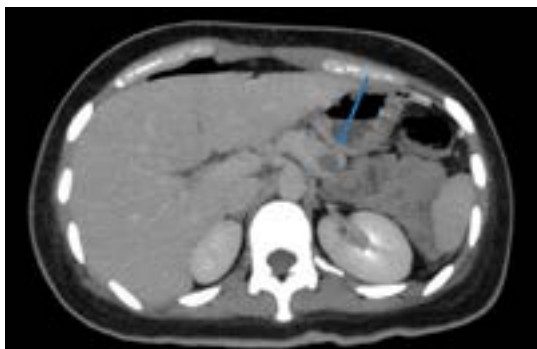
Abdominal computed tomography scan in axial view and venous phase of iodinated contrast medium, demonstrating the cystic lesion of the pancreatic body without significant enlargement and without late intra-abdominal complications.
